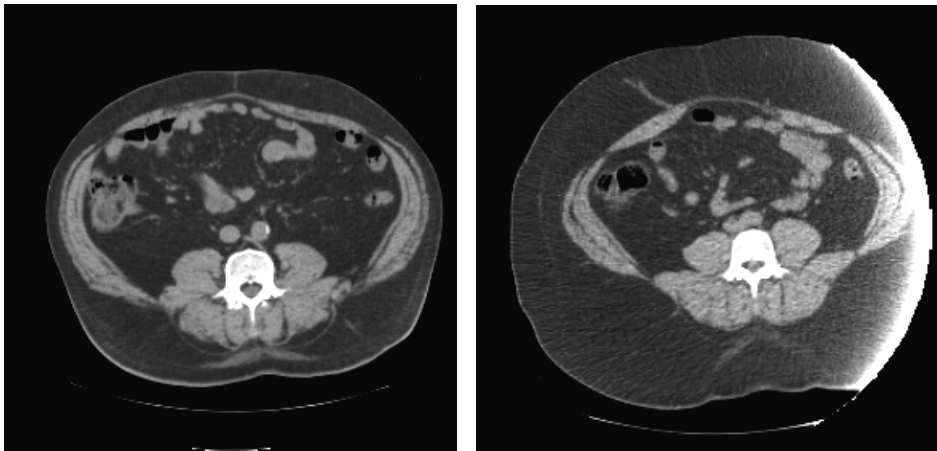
Computed tomography scan of the abdomen of two obese patients. The scans reveal the visceral adipose tissue that surrounds the internal organs within the abdominal cavity, and the subcutaneous adipose tissue beneath the skin. As seen in these pictures, there can be large differences in how fat is distributed between the two depots, with abundant visceral fat on the left CT-image, and a relatively high amount of subcutaneous fat on the right image.
